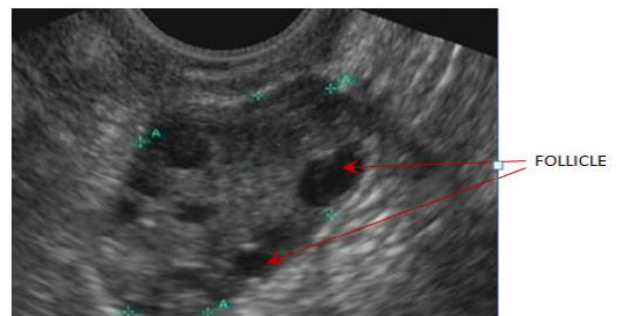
Ultrasound Image of an Ovary.
